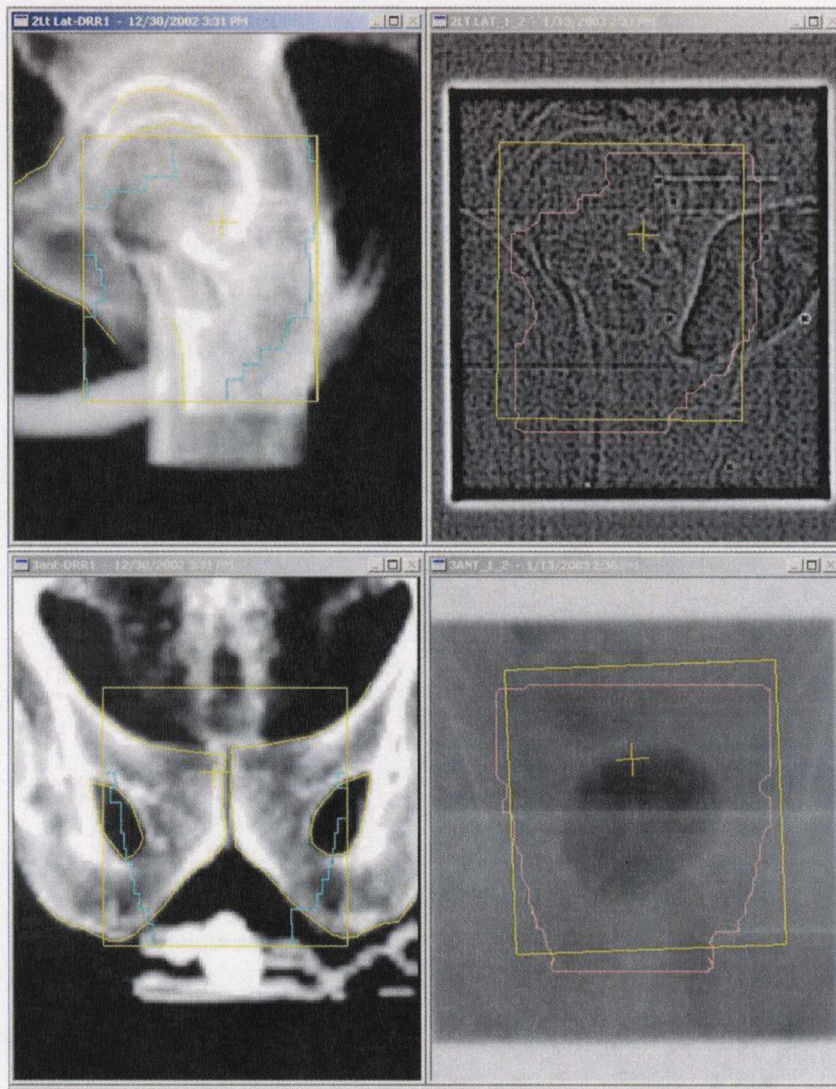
A digitally reconstructed radiograph (DRR) of a patient's hip using 80 kV photons (*top left*) and a portal image of the same area taken using 6 MV photons (*top right*). The difference in image contrast is due to the difference in dominant photon interaction processes. Similarly, a 80 kV DRR taken of a patient's pelvis (*bottom left*) and a 6 MV portal image of the same region (*bottom right*). One can see in this image a pocket of rectal gas appears clearly (due to a smaller effective attenuation length). One can also see that this patient is slightly misaligned on the treatment couch relative to where the planned radiation is to be delivered.
